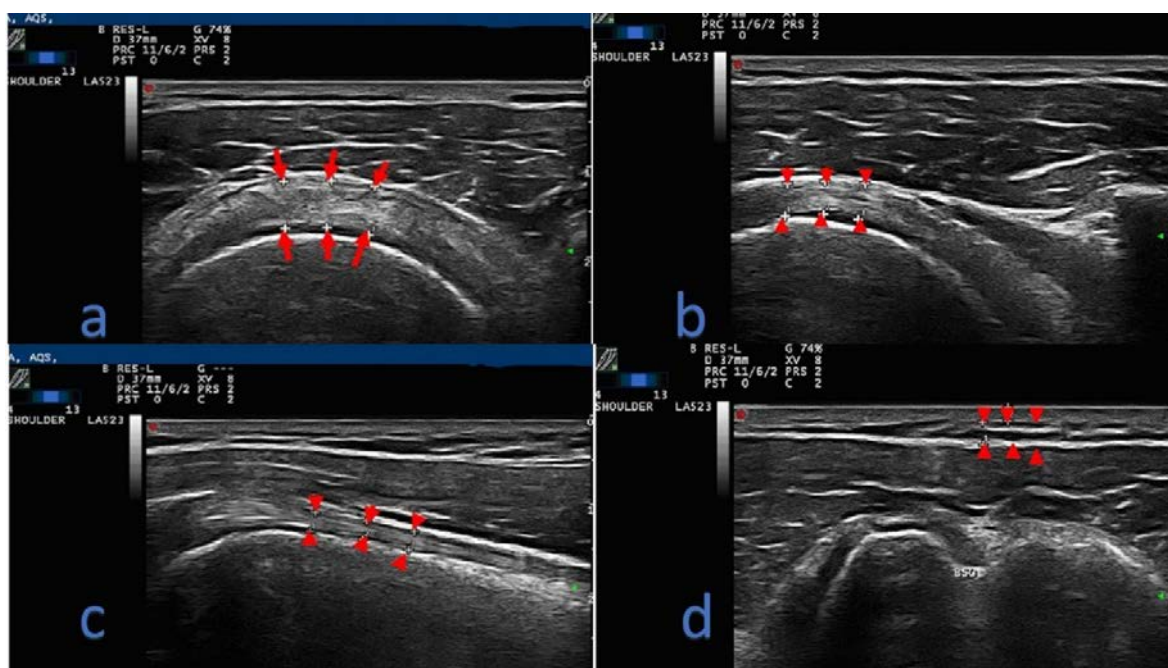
Ultrasonographic measurements. (a) Supraspinatus tendon, (b) Subscapularis tendon, (c) long head of the biceps tendon, and (d) Subcutaneous fat tissue.
